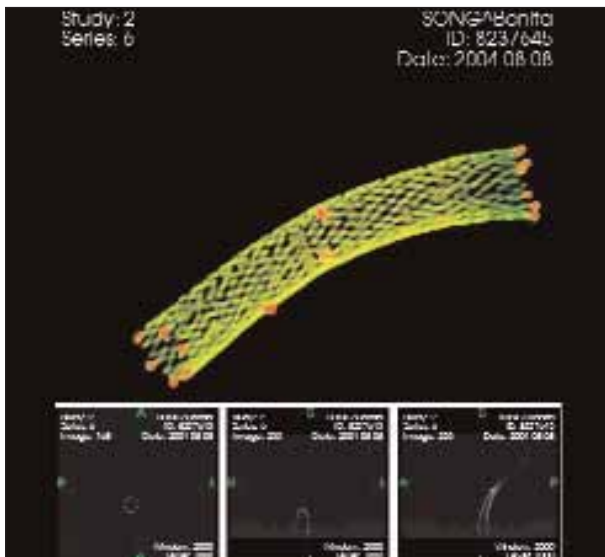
Detailed CT imaging of a self-expanding nitinol stent with copper markers for motion analysis.
